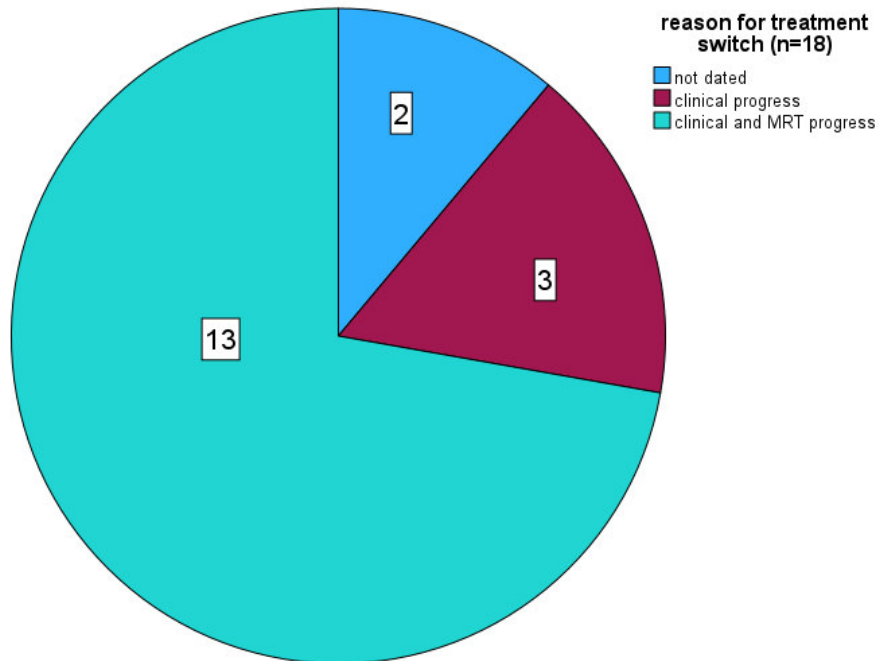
The reasons for switching from cladribine to another DMT are shown. All patients switched treatment due to either clinical or MRI activity.
